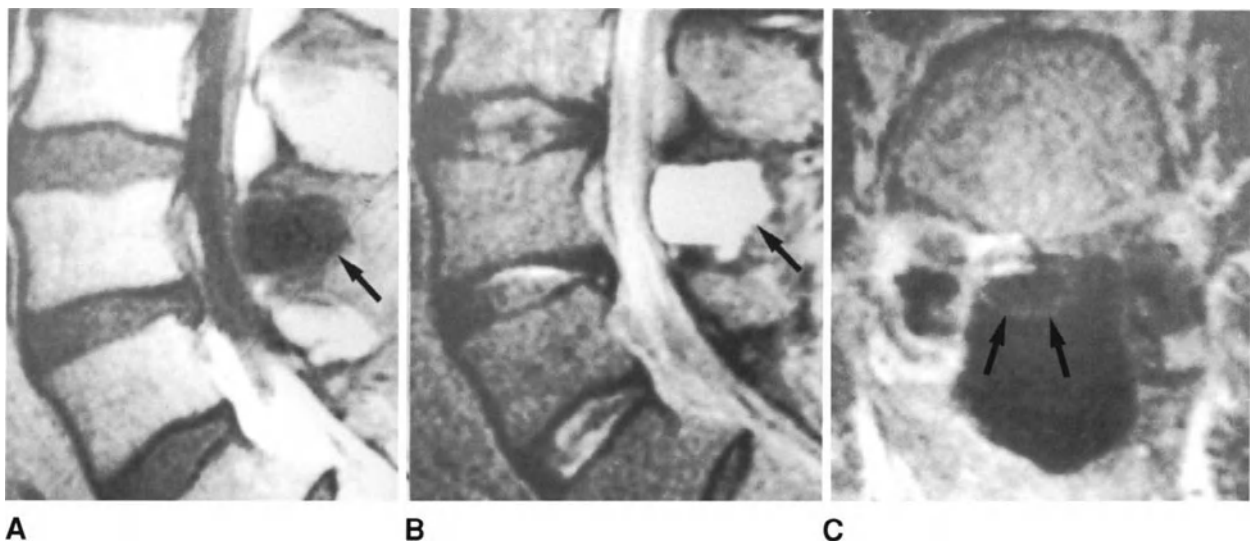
MRI scans of a patient with pseudomeningocele after bilateral laminectomy and discectomy at L4-L5 level. (A) and (B) Spin-echo T1-weighted and T2-weighted sagittal images, respectively, demonstrating a fluid collection at the operated level (arrows). (C) Spin-echo T1-weighted axial image which shows the close relationship between the liquid collection and the posterior portion of the thecal sac (arrows).
